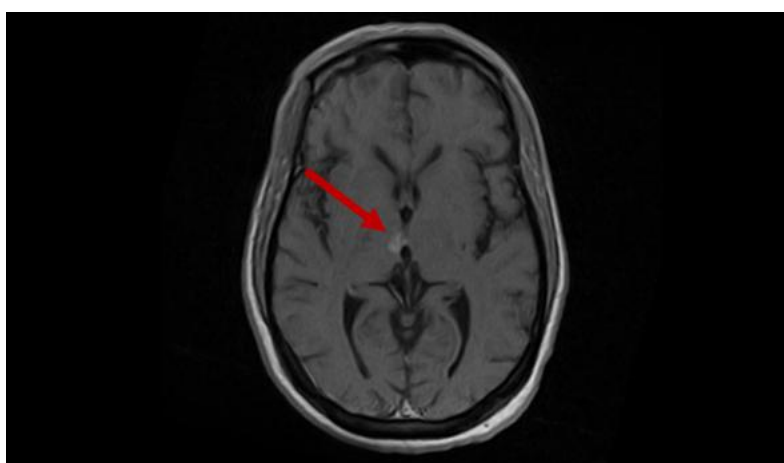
Axial T2-weighted brain MRI showing a hyperintense signal in the right mesencephalon.
